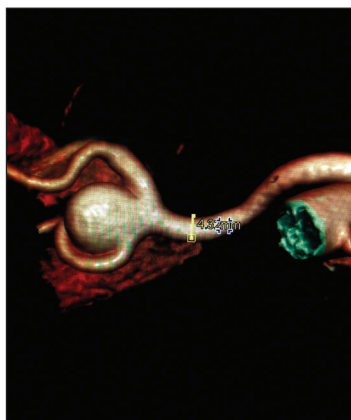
Volume-rendering CT reconstruction of the renal aneurysm showing the neck at the bifurcation.
